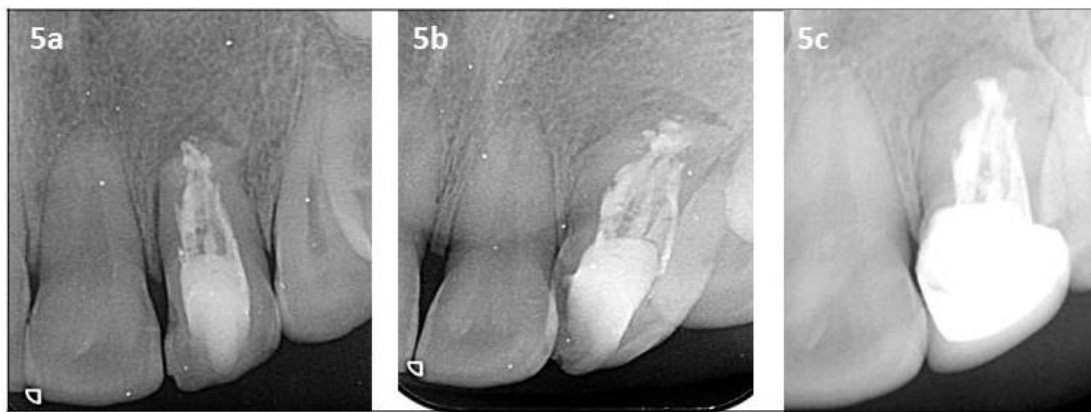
Post-operative periapical radiography with three different angulations
